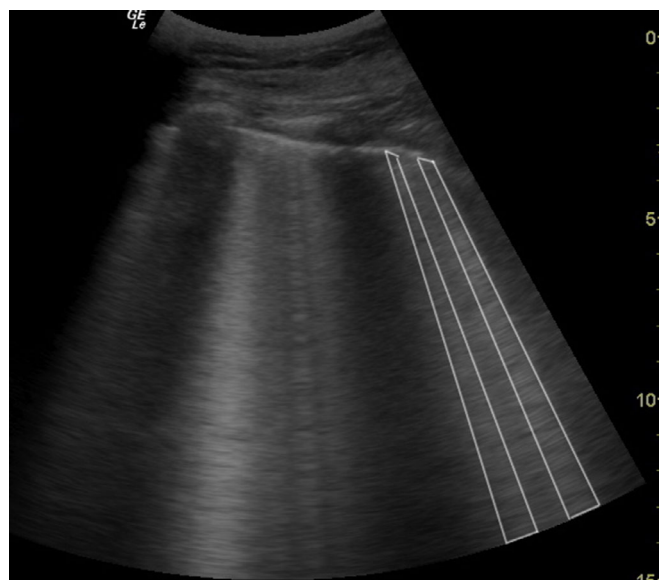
This curved probe with high focus shows a straight pleural line with multiple vertical B lines, two are outlined on the right. This is highly correlated with 'ground glass opacity' reported on CT scanning but is also seen in cardiogenic and non-cardiogenic pulmonary oedema, and fibrosing conditions with minimal pleural retraction. [Colour figure can be viewed at wileyonlinelibrary.com]
